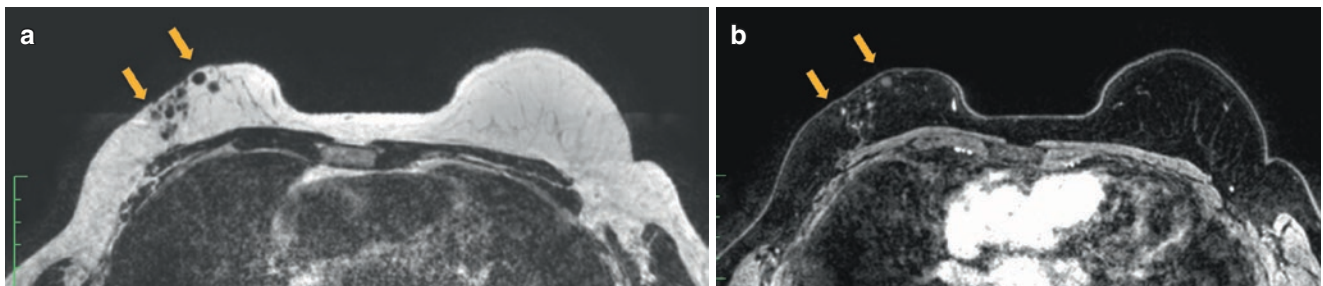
Patient with right breast-conserving surgery and lipofilling in UOQ. The patient presented with some new palpable lumps in that area after lipofilling (yellow arrows). MRI shows (a) several round lesions, most of them well defined, hypoechoic on T2 and (b) with a
